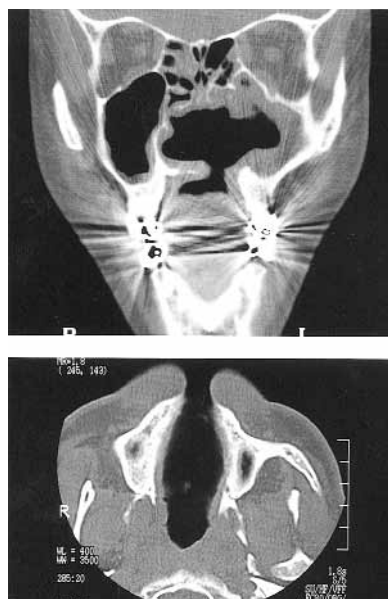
Computed tomography scan on coronal view showing the absence of vomer, nasal septum cartilage, left lateral nasal wall, and the palatal fistula. On sagittal view, the lip splitting.
